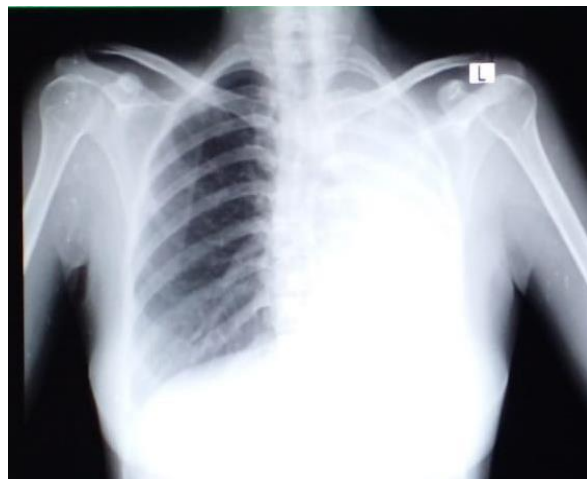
chest xray PA view showing left sided homogenous opacity.
